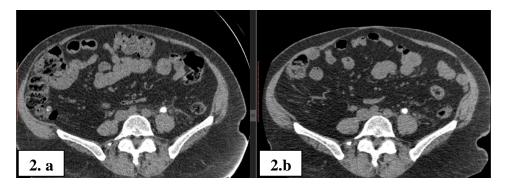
(A, B): CT of the urinary tract revealed left lower Ureteric stone. (a) Stone appeared by standard dose computed tomography (120 kV, 420 mAs). (b) The same stone appeared by low dose computed tomography (80 kV, 130 mAs).
